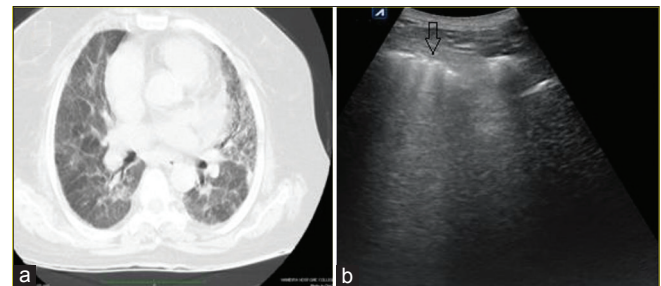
(a) High resolution computed tomography of the chest in a patient with interstitial lung disease showing left lung ground-glass opacity. (b) Transthoracic sonography of the same patient showing multiple B lines arising from a thickened and irregular pleural line (black arrow)
